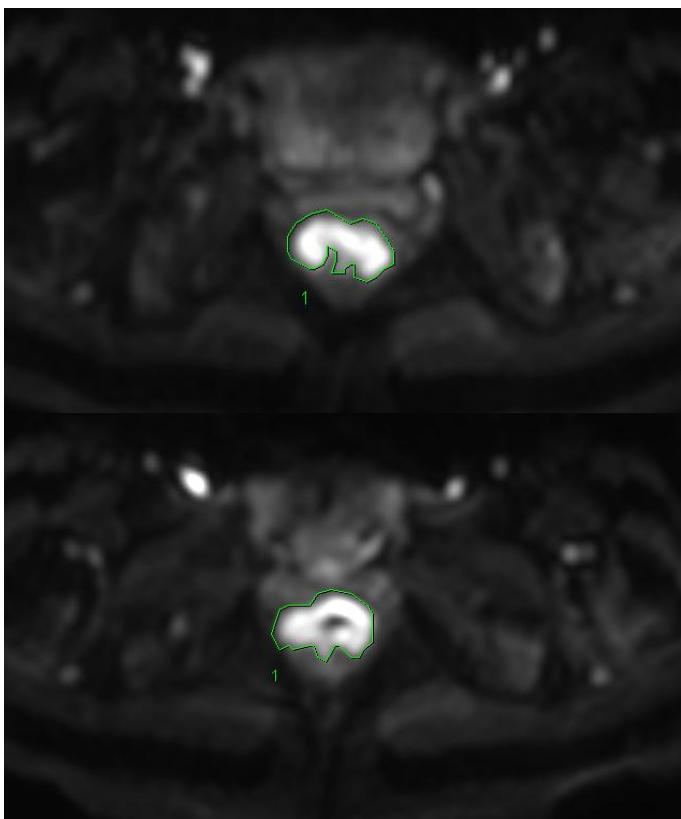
Tumour volumetry as performed on DWI ($b = 800$)
